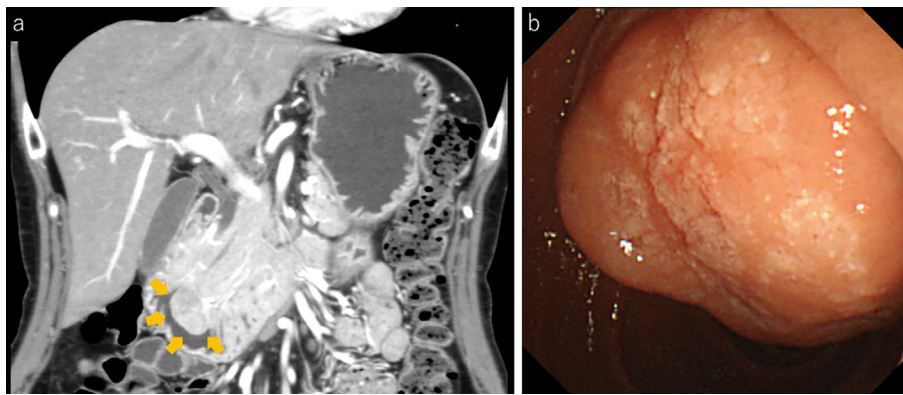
(a) Contrast-enhanced computed tomography image showing a hypervascularized tumor in the ampullary region (yellow arrow). No bile or pancreatic duct dilatation was observed. (b) Duodenoscopy revealed a markedly enlarged papilla of Vater.
